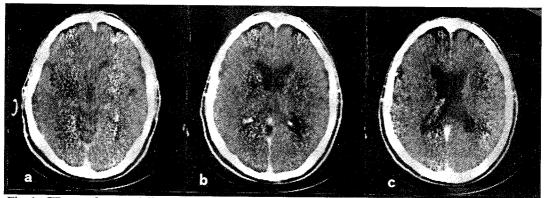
CT-scan showing diffuse, mild, cortical and subcortical atrophy. a, b and c are three tomographic sections of a dorsoventral series, which are spaced approximately 15 mm from each other.
